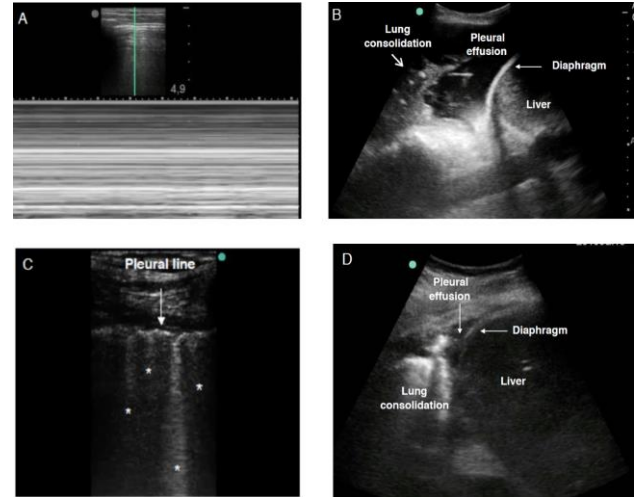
Abnormal ultrasound patterns. A) Pneumothorax. Image in M mode shows the ‘stratosphere sign’ or ‘barcode sign’; B) Pleural effusion and pulmonary consolidation. An anechoic chamber is observable, corresponding to the pleural effusion, adjacent to the consolidated lung, which contains hyperechogenic images that are consistent with an aerial bronchogram; C) Interstitial lung disease. Several B-lines, or ‘comet tails’ can be seen (*) which originate at the pleural line; D) Pulmonary consolidation with small adjacent pleural effusion.
